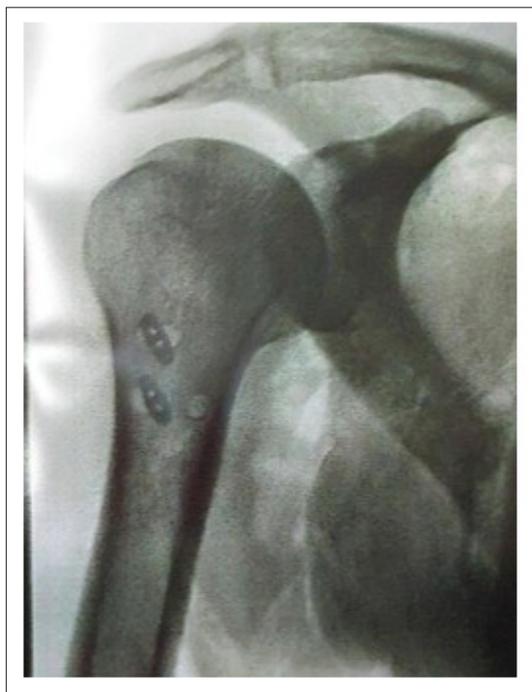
Radiograph shows cortical buttons fixed using two unicortical fixation technique.
